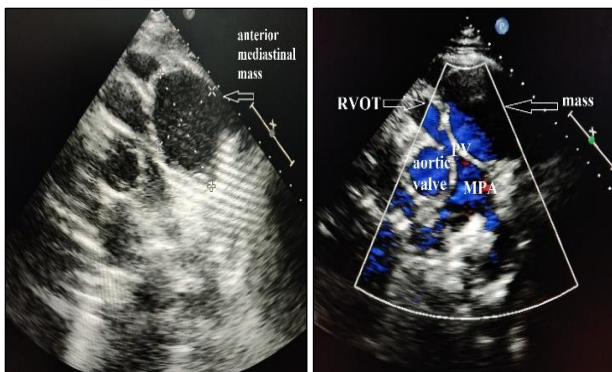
The 2D echocardiography showed anterior mediastinal mass compressing main pulmonary artery (MPA).
